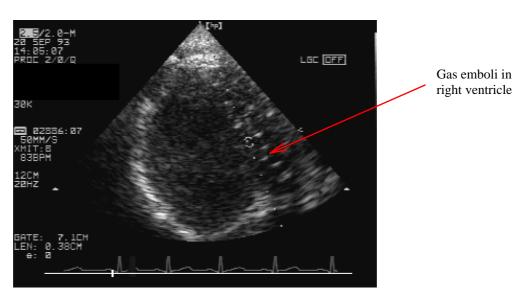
Echocardiograph from a subject at 30,000 ft breathing 100% oxygen following denitrogenation – several gas emboli are present in the right ventricle of this subject.
